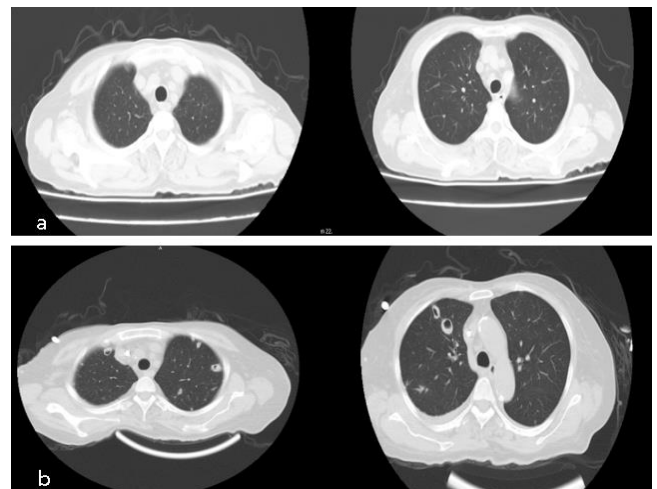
Bilateral cavitary lesions and nodular appearances on the new CT scan, compared with a previous CT scan of the patient
